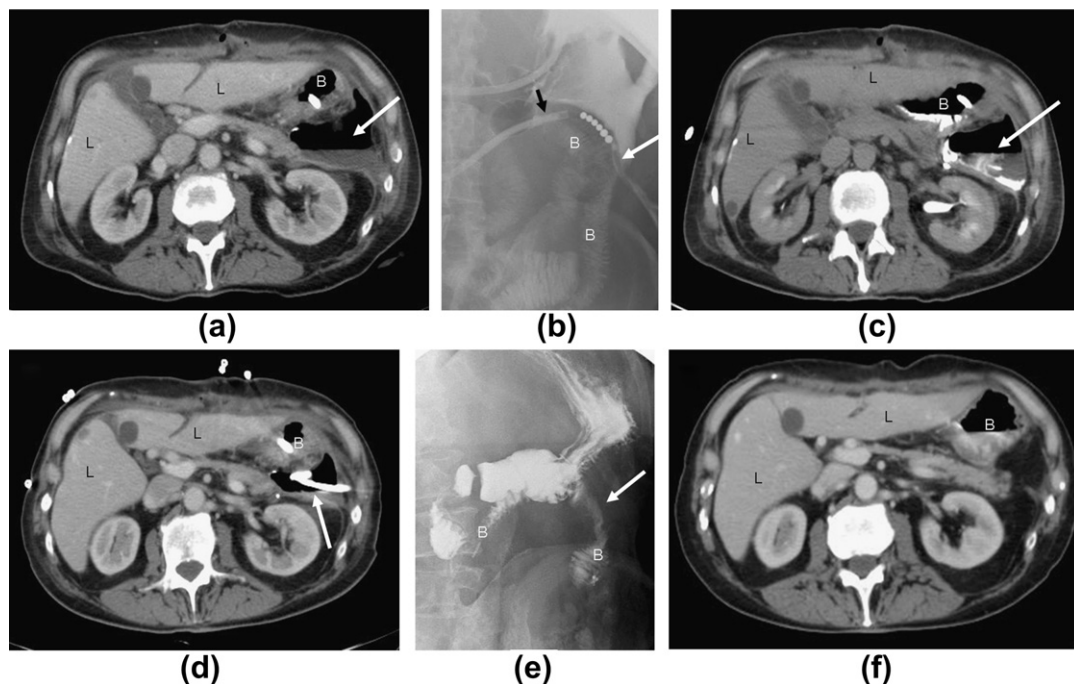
Treatment of an enteric fistula in a patient who underwent partial colon resection for colon cancer. (a) A CT examination 7 days after surgery demonstrated an air–fluid collection (arrow) in the left paracolic space. L, liver; B, bowel. (b) A contrast enema demonstrated the presence of an enteric fistula at the Trietz level (white arrow). B, bowel; black arrow, naso-jejunal tube. (c) A CT examination demonstrated the presence of contrast material in both the bowel (B) and the fluid collection after the ileal enema (arrow). L, liver. (d) A CT-guided percutaneous drainage (arrowheads) was placed into the fluid collection, with the tip of the drainage catheter close to the site of the fistula and, Glubran2 was injected after collection resolution. B, bowel. (e) An ileal enema demonstrated the occlusion of the fistula. Arrow indicates the location of previous fistula; B, bowel. (f) A CT examination 13 months after the procedure demonstrated complete resolution of the fistula. B, bowel; L, liver.
